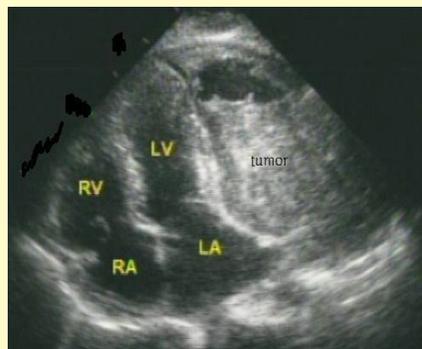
An apical two-chamber echocardiograph showed a huge mass with central necrosis inside the pericardium, causing tamponade of the left ventricle (LV: left ventricle; LA: left atrium; AO: aortic outlet).
